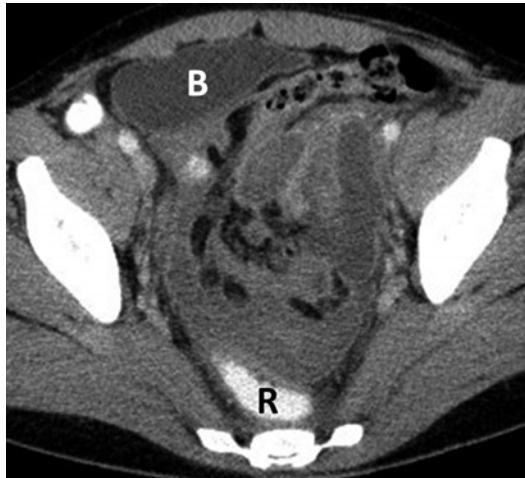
Diffuse pelvic hematoma 10 days after hysterectomy. Transaxial CT demonstrates encapsulated lesions with thin peripheral enhancement throughout the pelvis. They are surrounding the bowel and follow the tissue planes along the pelvic sidewalls. HU ranging from 20 to 50 HU and lack of air support the diagnosis of subacute hematomas. Bladder (B), rectum (R)
